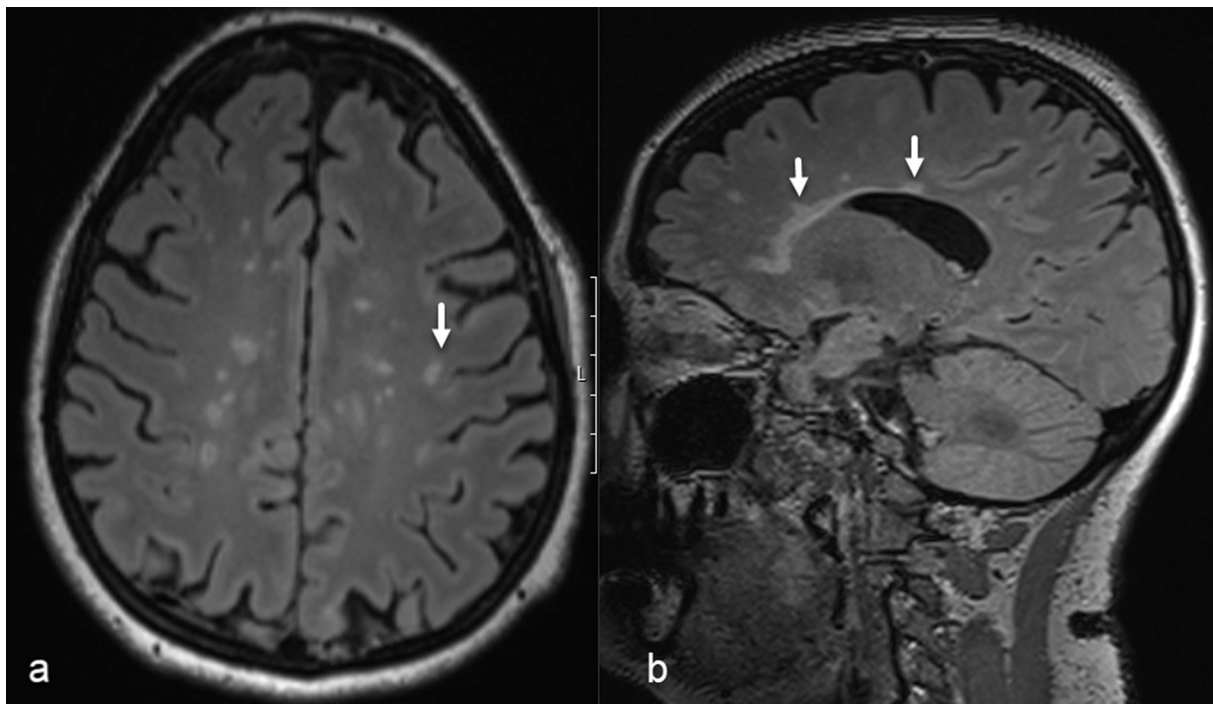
A: Axial FLAIR-weighted MR scan showing multiple hyperintense lesions in the deep white matter and a juxtacortical lesion (arrow). Abbreviations: FLAIR: Fluid attenuated inversion recovery; MR: magnetic resonance.
